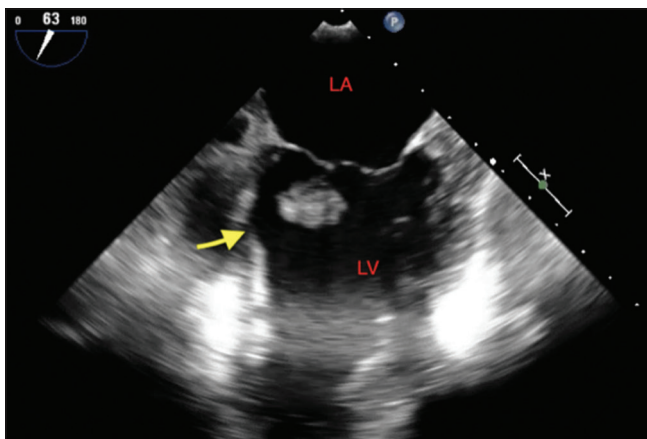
Transesophageal echocardiography. Midesophageal commissural view with myxoma (arrow). LA: Left Atrium, LV: Left Ventricle
